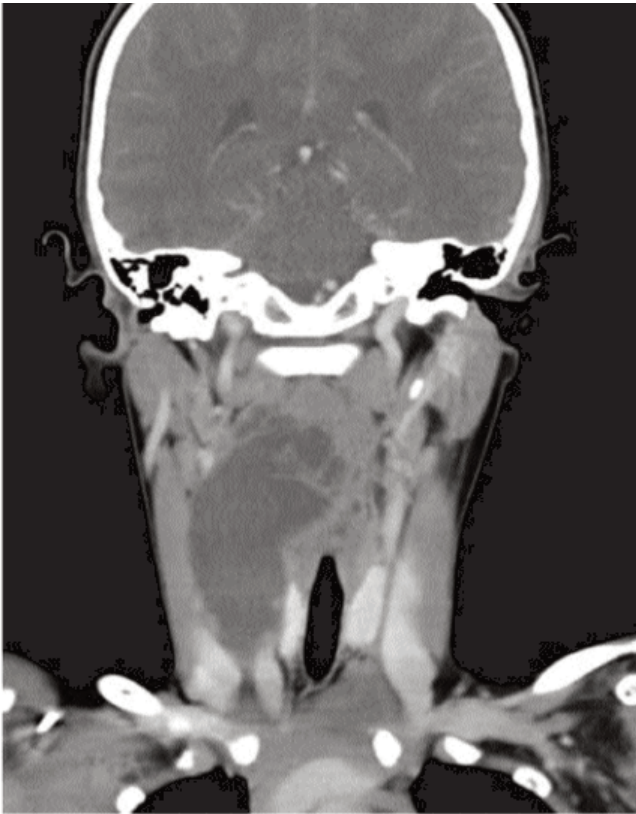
CT-Scan axial cut showing a non-enhancing image involving the parapharyngeal space.
